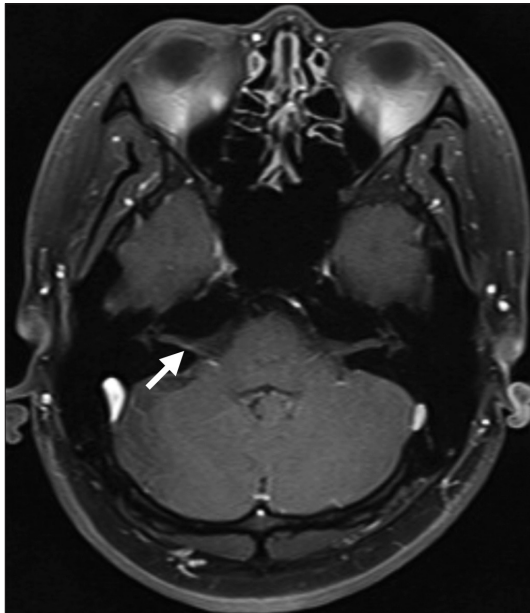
Axial T1-weighted magnetic resonance imaging of the brain. The white arrow indicates a faint focal high signal on contrast-enhancement along the 7th and 8th intracanalicular nerve segment.
